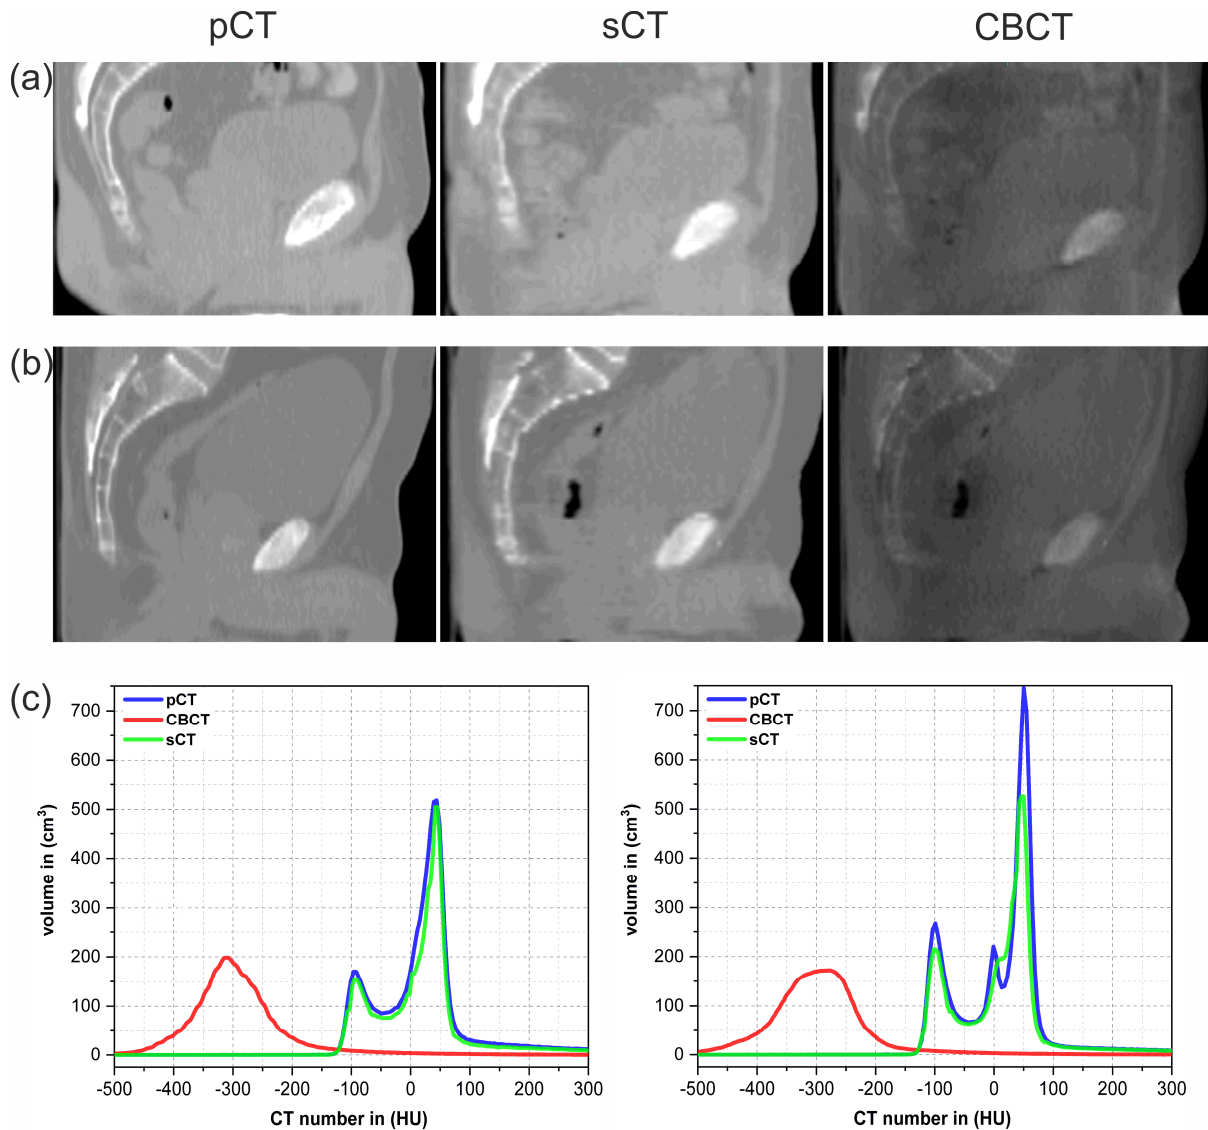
Planning CT (pCT), cone-beam CT (CBCT) and synthetic CT (sCT) of two exemplary patients (panel (a): Patient P14, panel (b): Patient P10) with window level settings of [-900 700] HU. Panel (c) depicts intensity-volume-histograms (IVH) for the pCT, CBCT and sCT for the body contour VOI minus a 15 mm margin.
